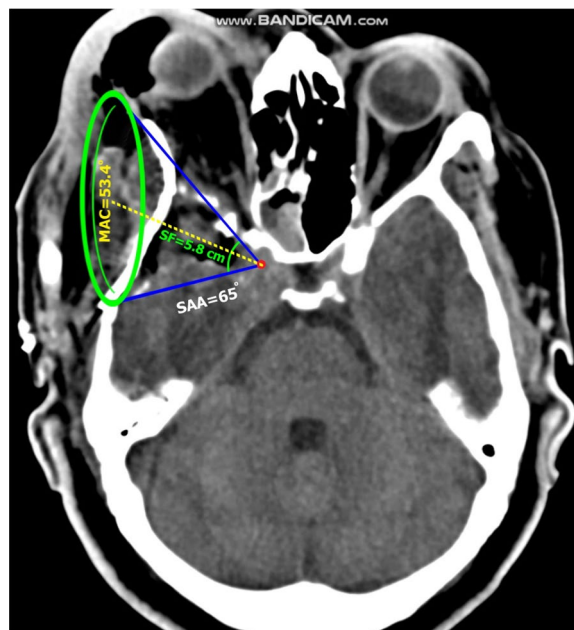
Postoperative non-contrast CT scan of the pterional approach with anterior clinoidectomy “PAAC+”, showing measurements of operability score parameters (MAC, SAA, SF)
